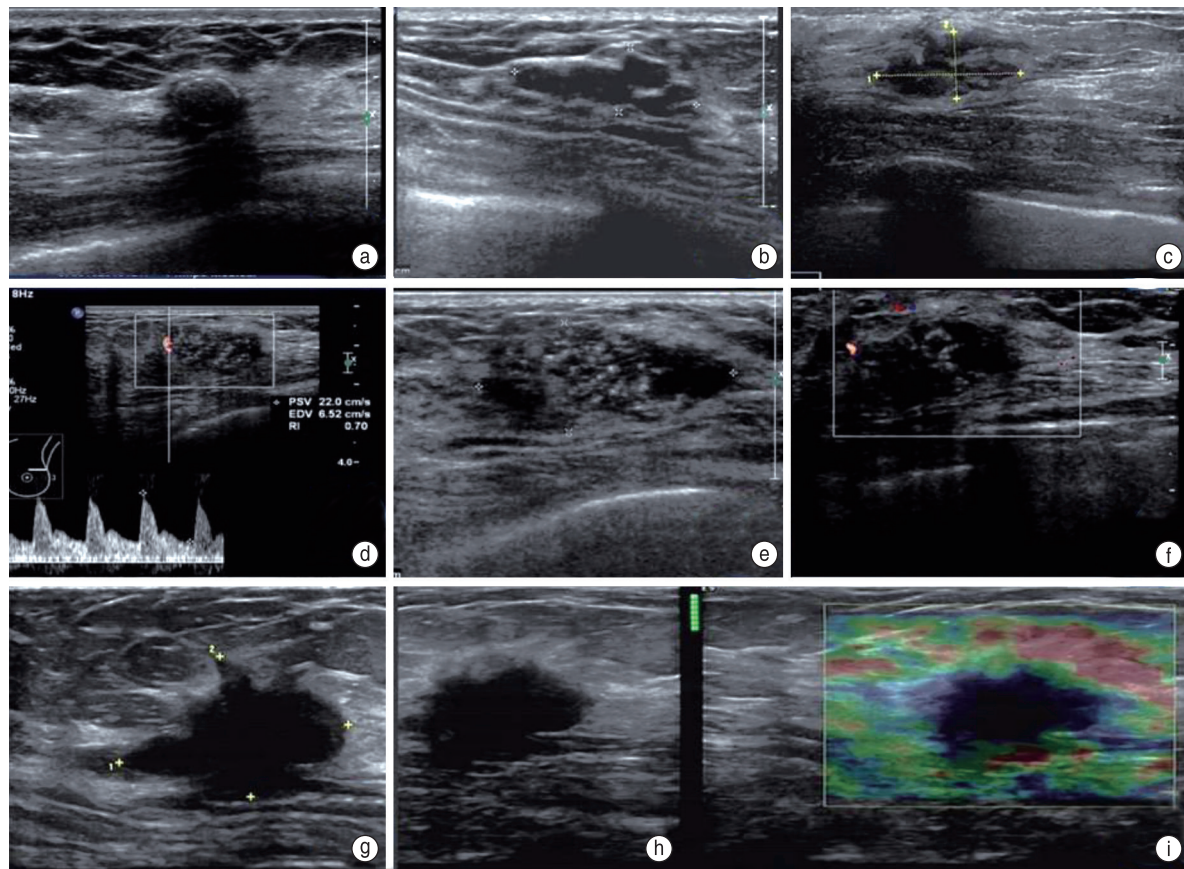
BI-RADS on ultrasonography. (a) BI-RADS 3 (benign lesion). The echo inside the mass was not homogeneous, boundary was still clear, and ring echo around the mass was strong; (b) BI-RADS 4a (benign lesion). The internal echo of the mass was not homogeneous and the boundary was still clear, but the edge was irregular; (c) BI-RADS 4b (invasive ductal carcinoma II). The echo inside the mass was not homogeneous, boundary was not clear, edge was irregular, and echo behind the mass was weak; (d, e, and f) BI-RADS 4c (invasive ductal carcinoma III with ductal carcinoma in situ). Hypoechoic mass, heterogeneous internal echo, punctate calcification with strong echo, and unclear boundary were observed. CDFI showed short rod blood flow signal in the mass; (h and i) BI-RADS 5 (invasive ductal carcinoma II). The shape of the nodule was irregular, edge was not smooth, burr sign was visible, internal echo was weak, punctate strong echo was visible, signal behind the nodule was attenuated, and surrounding gland structure was twisted. Elastography showed that the tubercle was hard. CDFI showed the blood flow signal in the border area of the nodule
